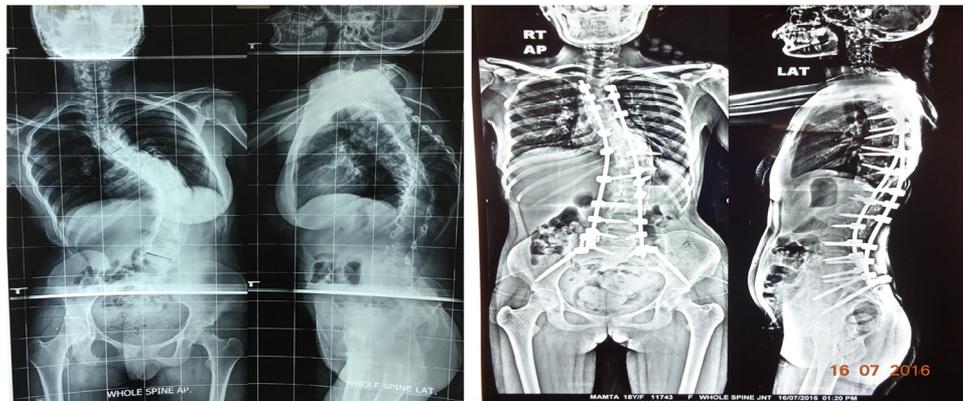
Pre- and postoperative x-rays of one patient with congenital scoliosis operated on with the help of 3D printing. 3D, three-dimensional.
